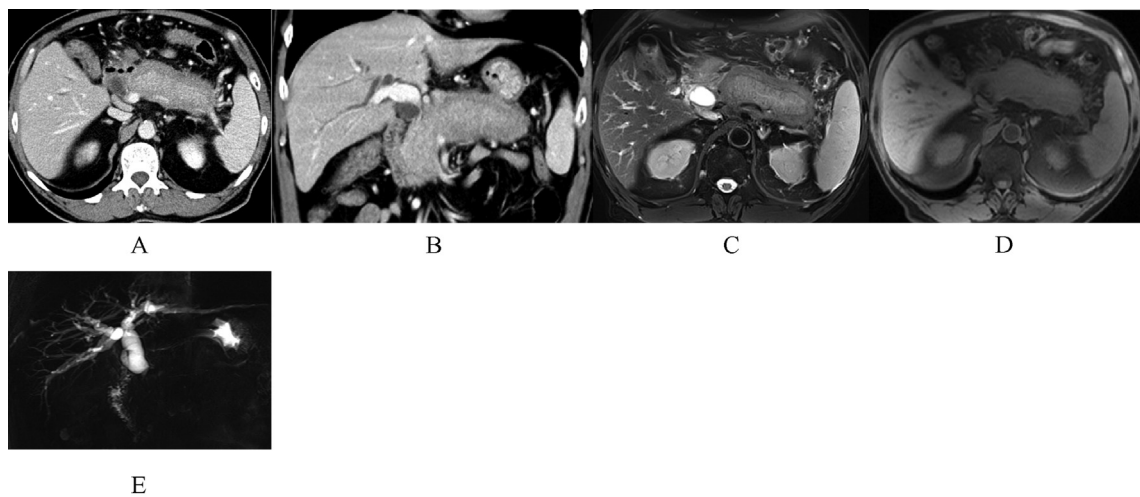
M/63. Diffuse AIP. Venous phase CT image (A) showed diffuse enlargement, with a low density halo and stenosis of splenic vein. Venous phase coronal reconstruction (B) showed stenosis of intrapancreatic portion of the common bile duct and thickening of wall. MR T2WI TSE (C) and FS T1WI (D) images showed diffuse enlargement and a hypointensity halo. MRCP (E) showed multiple narrowing of pancreatic duct without upstream duct dilatation, and cutting stenosis of intrapancreatic portion of the common bile duct with obvious dilatation of intrahepatic and extrahepatic bile duct.
